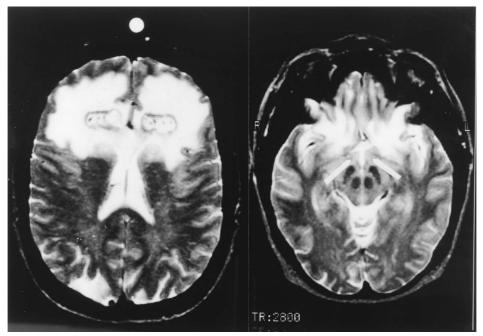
A: an axial MRI view in a frontal tractotomy patient. The yttrium deposits bilaterally are surrounded by a small area of radio-necrosis, and there is a much larger area of oedema which always spared the cortical margin. B: shows a lower axial cut at the level of the septal nuclei (indicated), which were spared, as were the other basal forebrain structures (compare Newcombe (1975)).
